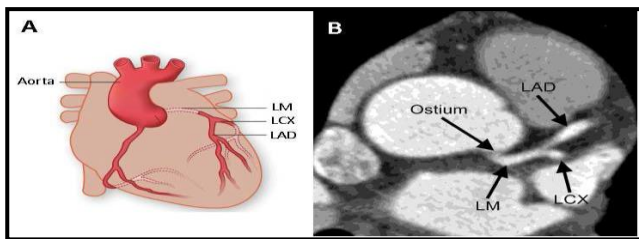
(A) Aorta and LCA anatomy. (B) Example of a CT slice image showing the coronary ostium, the left main artery (LM), the left anterior descending (LAD) and the left circumflex (LCX) branches [10].
